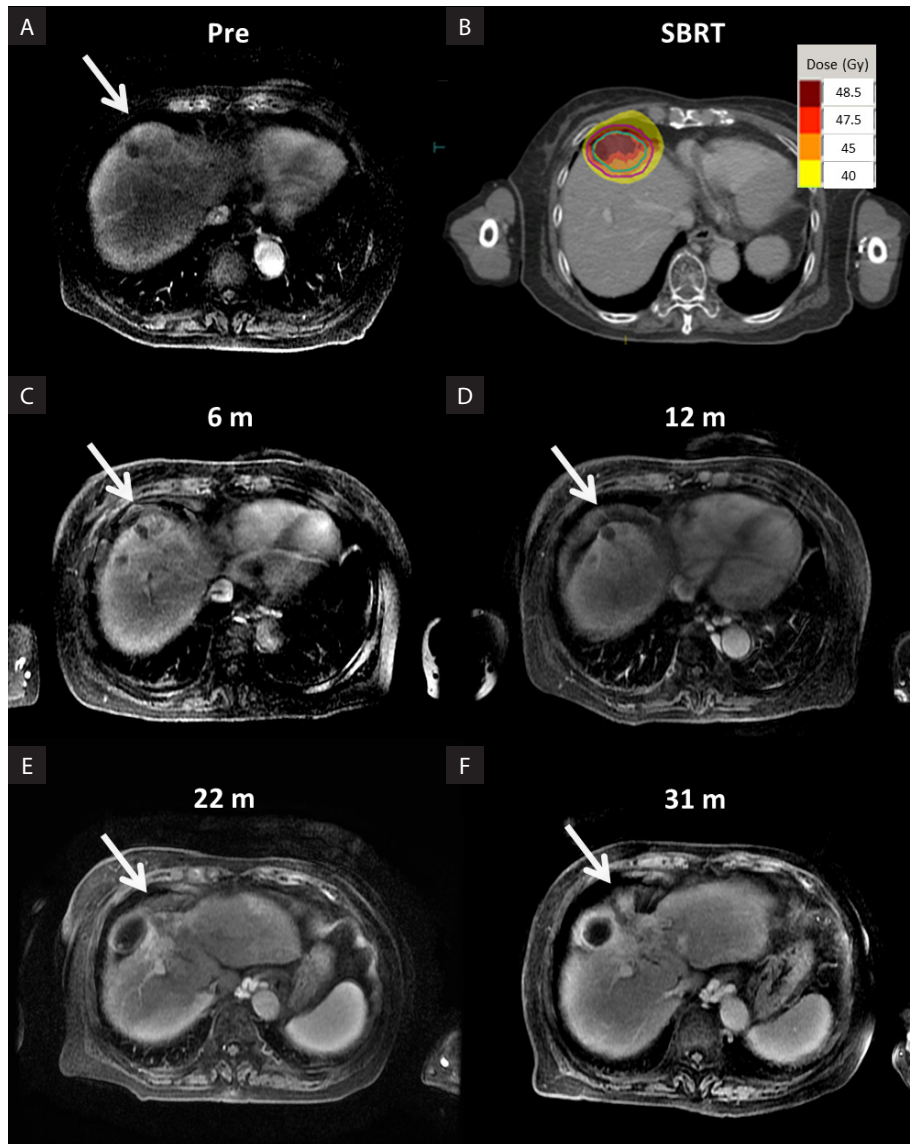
Complete response after stereotactic body radiotherapy (SBRT). Images of an 80-year-old patient who underwent SBRT with 45 Gy to a single 4 cm lesion (white arrow). A. Pre-treatment magnetic resonance imaging (MRI); B. SBRT isodose curves. C–F. Follow-up MRIs showing continuous reduction of the treated lesion. In images (C) and (D), transient alterations due to lower isodoses are seen in surrounding liver parenchyma. In images (E) and (F), the gallbladder, with its characteristic homogeneous contrast enhancement, is seen to the right of the arrow. Images are not at the same level due to changes in liver size and shape
